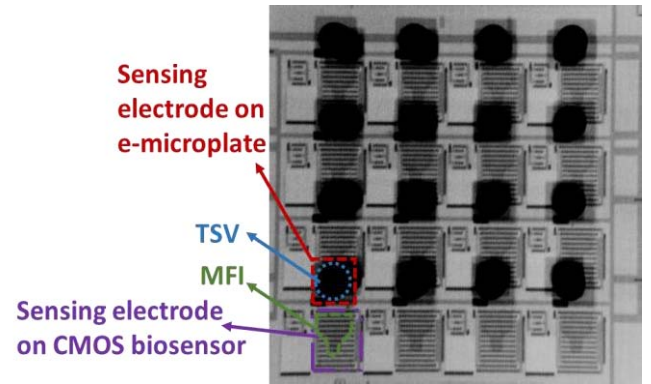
X-ray image showing accurate alignment between e-microplate and CMOS biosensor.
